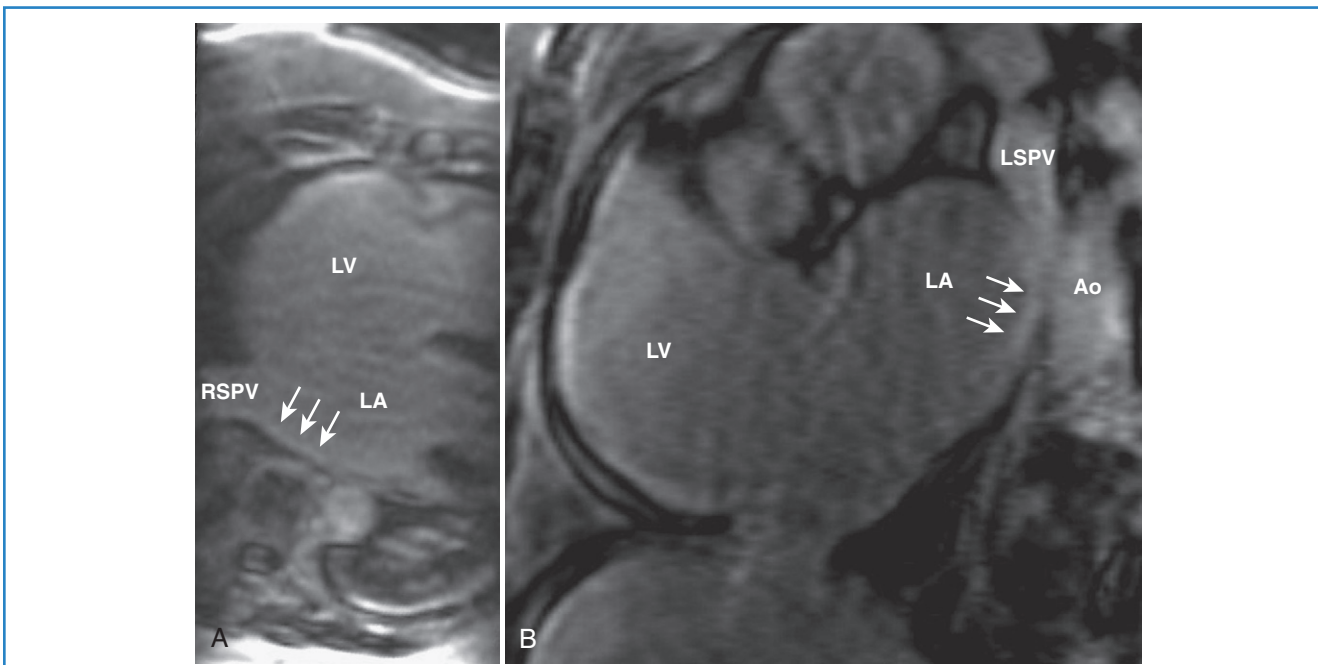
Left atrial ablation lesions. A, Horizontal long-axis magnetic resonance imaging (MRI) view of a patient 5 months after pulmonary vein (PV) isolation demonstrating areas of delayed enhancement (*arrows*) around the right superior PV (*RSPV*) representing LA scarring. B, Oblique short-axis MRI view with delayed enhancement (*arrows*) around the left superior PV (*LSPV*). *Ao*, aorta; *LA*, left atrium; *LV*, left ventricle. (Courtesy Dr. Jean Jeudy.)
